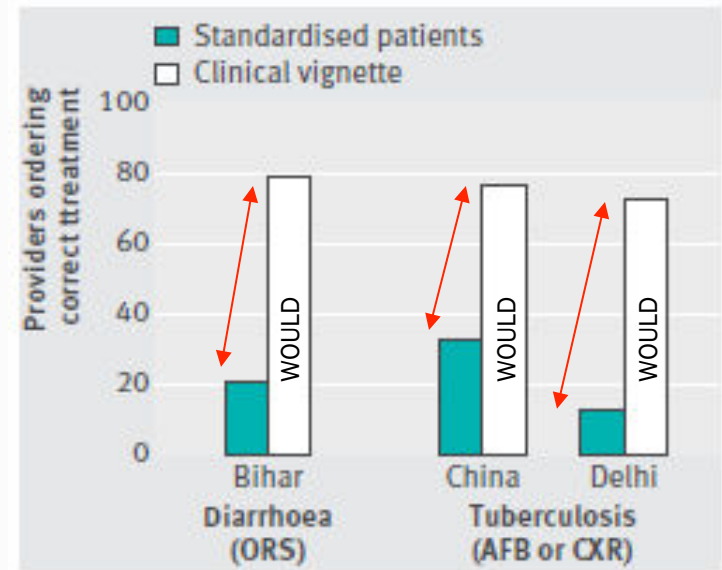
Differences between how providers said they would manage diarrhoea and tuberculosis in clinical vignettes and what they actually did with standardised patients presenting with the symptoms in the vignettes (ORS=oral replacement solution, AFB=acid fast bacilli test, CXR=chest radiography) ^{13 17 30}
